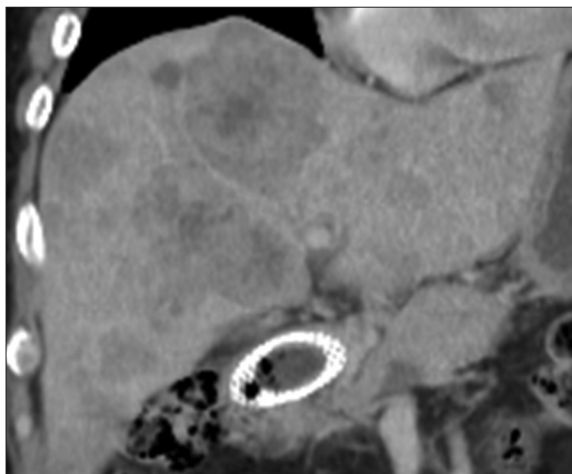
Computed tomography before nivolumab showed heterogeneous liver metastases
